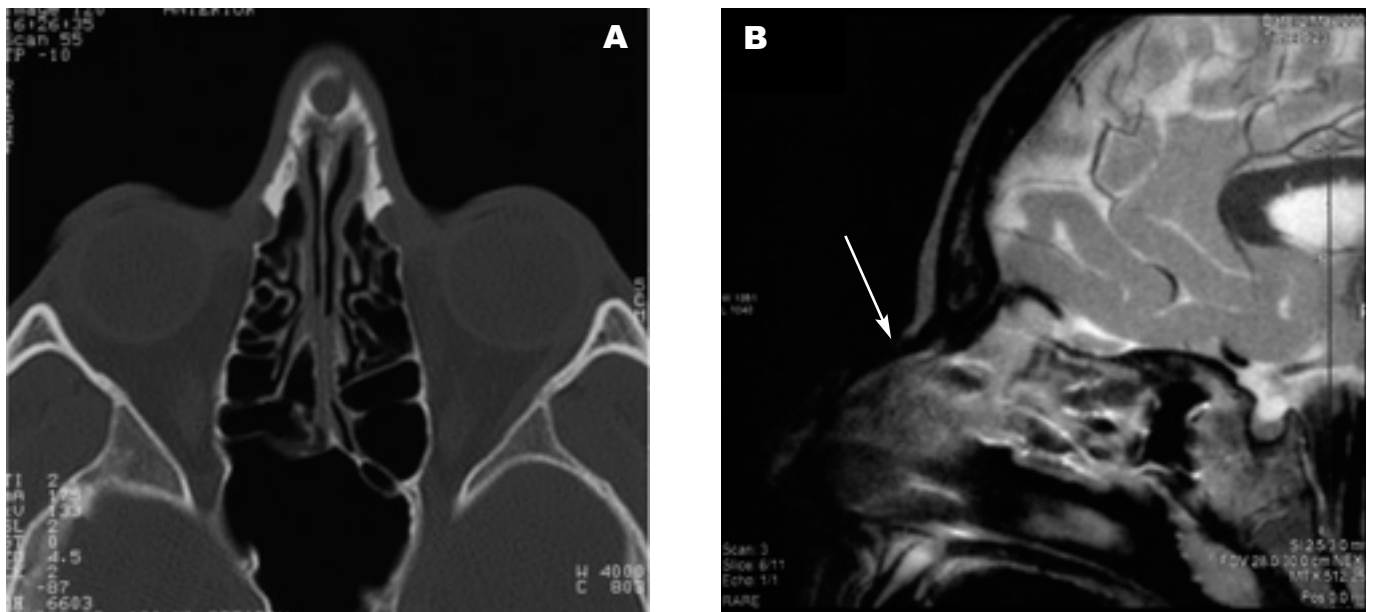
NDSC A: Fistula located within the nasal bone (CT) B: Fistula running underneath nasal bone (white arrow head; MRI).
